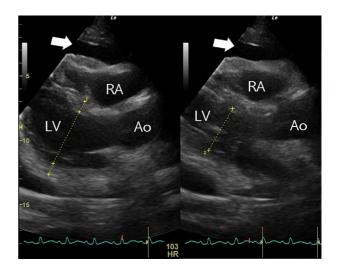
A transthoracic echocardiogram (TTE). Diastolic collapse of the right ventricular free wall and pericardial effusion (arrow) can be visualized. RV: right ventricle, LV: left ventricle, Ao: aorta
